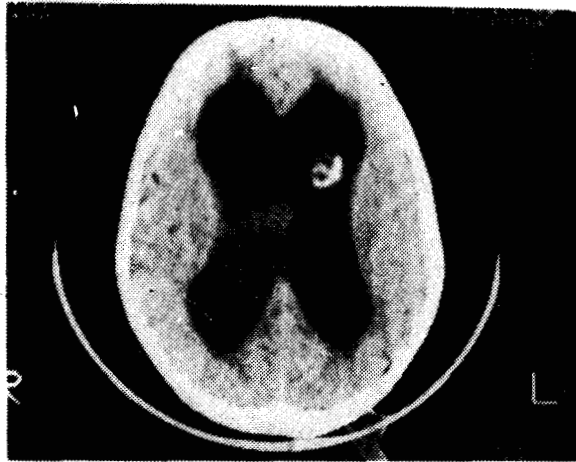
Post contrast CT head scan revealed.
